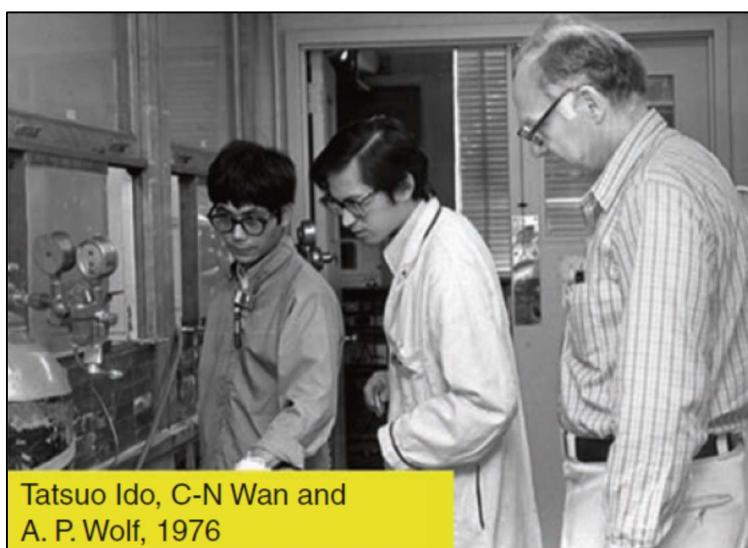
Inventors of FDG, Tatsuo Ido, Chung Nan Wan, and Alfred Wolf
